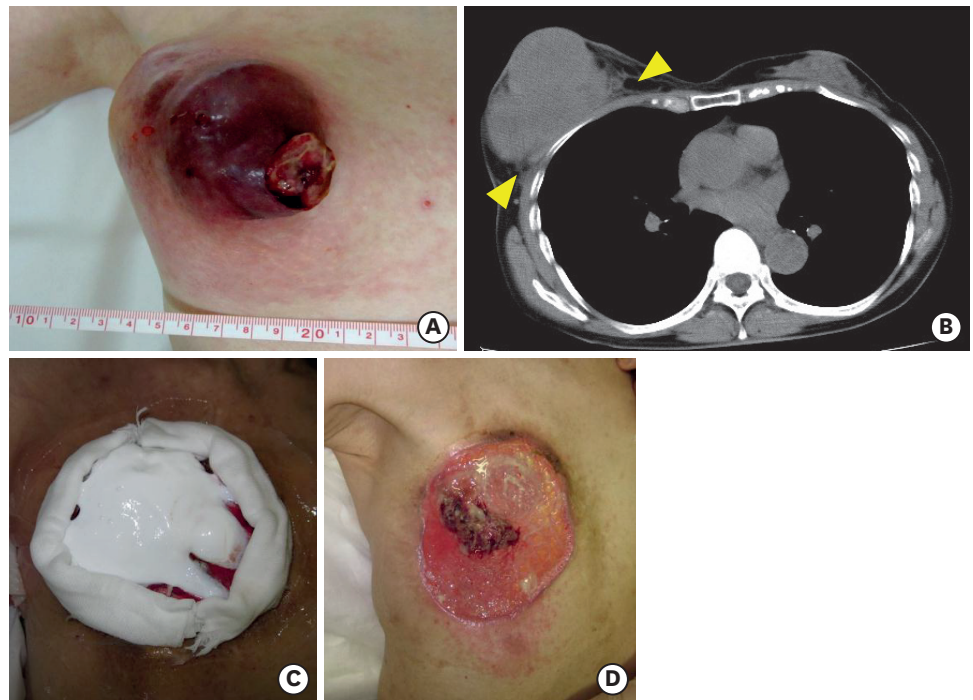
Macroscopic and CT image of the right breast at the initial visit and Mohs chemosurgery. (A) The tumor was approximately 13 cm with cutaneous infiltration mainly in area C of the right breast. Mobility was poor, and axillary lymph nodes were swollen. (B) CT revealed a mass with infiltration of the pectoralis major muscle (yellow arrowhead). (C) First, petroleum jelly was applied to the surrounding normal skin, and then Mohs paste was applied to the tumor and removed again after 24 h for observation of the tumor, with the cycle repeated as necessary. (D) Macroscopic image of the right breast before surgical treatment. The tumor was fixed by the effect of the Mohs paste, and necrotic tissue was removed bluntly. The process of applying paste, performing observation, and sacrificing necrotic tissue was repeated for 10 months. As a result, most of tumor was shaved off, until only a small amount remained in the center. CT, computed tomography.
